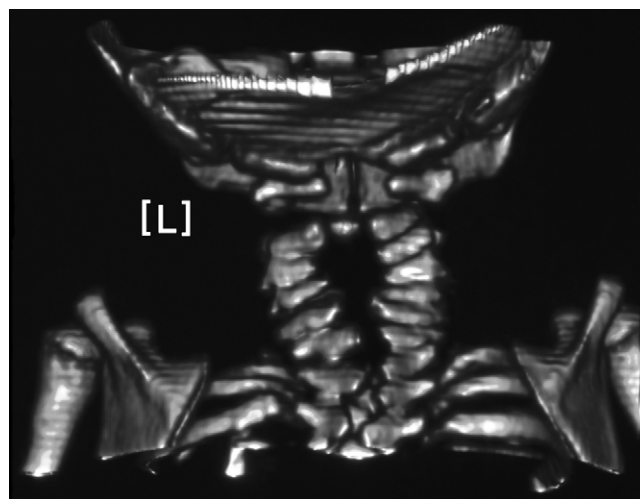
Posterior view of three-dimensional reconstruction of cervical spine computed tomography. Asymmetrical laminae, perched facets, and anterior and posterior rachischisis are present.
